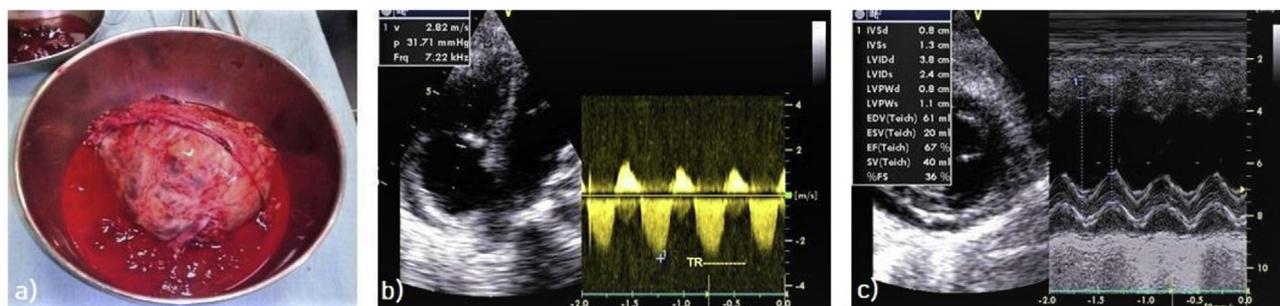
Postoperative images showing a) macroscopic view of the excised hydatid cyst, b) transthoracic echocardiography image showing mild postoperative tricuspid regurgitation (right ventricular pressure 31 mmHg) and, c) M-mode transthoracic echocardiography image showing a normal size and good contractility of the left ventricle.
